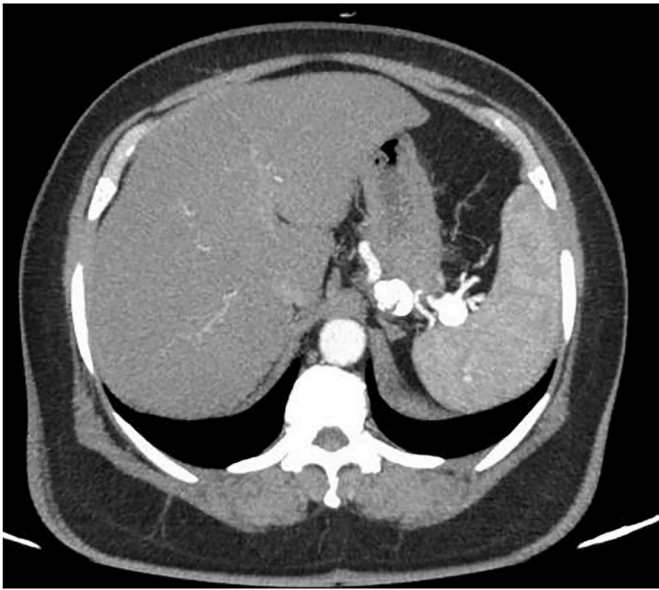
Axial abdominal CT scan picture showing two splenic artery aneurysms localized on the splenic hilum: The proximal one measured 20 mm in diameter and the second was distal to the first one with a calcified wall and measured 15.5 mm.
